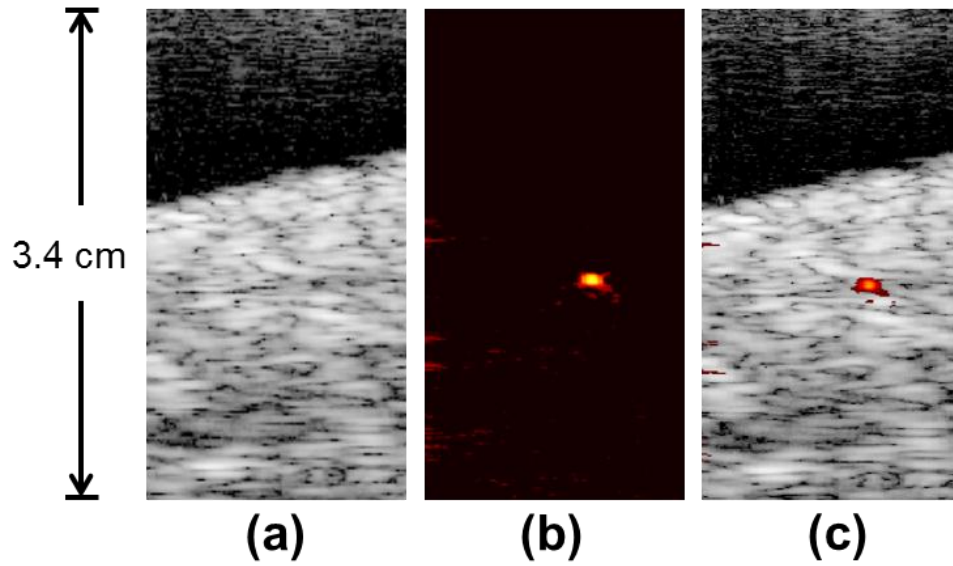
Images of hypodermic needle inserted angled approximately 15° with respect to horizontal. Needle is repositioned in the same tissue from Figure 4. Transducer is oriented at the top of the images. (a) Ultrasound image of tissue containing needle cross-section. The angled needle is not visible. (b) Photoacoustic image of same cross section as (a). The highly absorbing needle appears very clearly. (c) Combined US and PA image showing the exact location of the needle within the tissue. Ultrasound images are displayed at 40 dB, photoacoustic images 20 dB. Since ultrasound and photoacoustic images are obtained at the same position, the two images are spatially co-registered.
